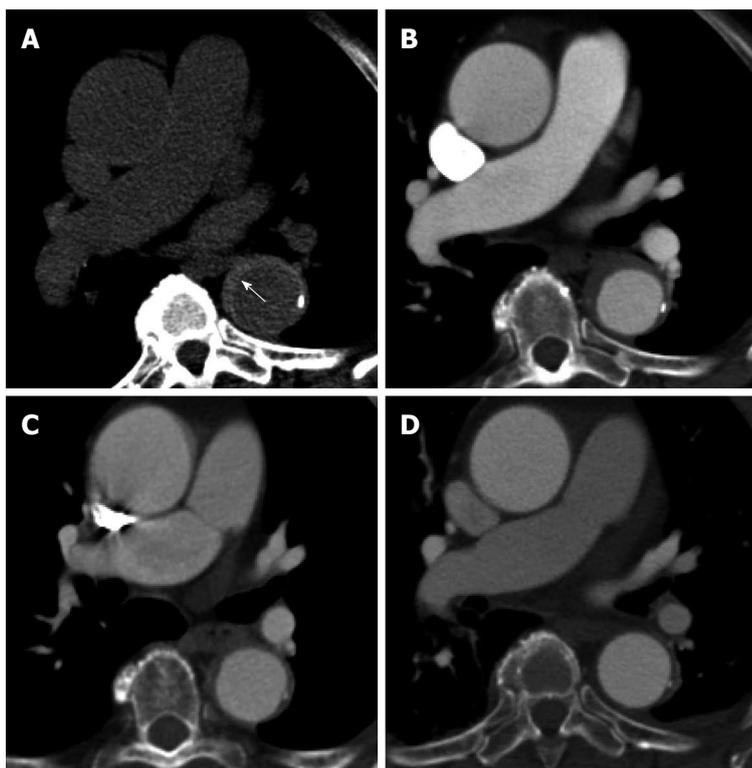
A 61-year-old lady with severe chest pain, breathlessness and a prior history of atrial flutter. Computed tomography aortogram in the emergency department shows hyperdense, eccentric wall thickening of the aortic wall consistent with an intramural haematoma (A, white arrow). A concurrent contrast enhanced axial image at the same level shows no leakage of contrast into this thickened aortic wall (B). The intramural haematoma shows partial resolution at 1 mo (C) and complete resolution at 6 mo (D).
